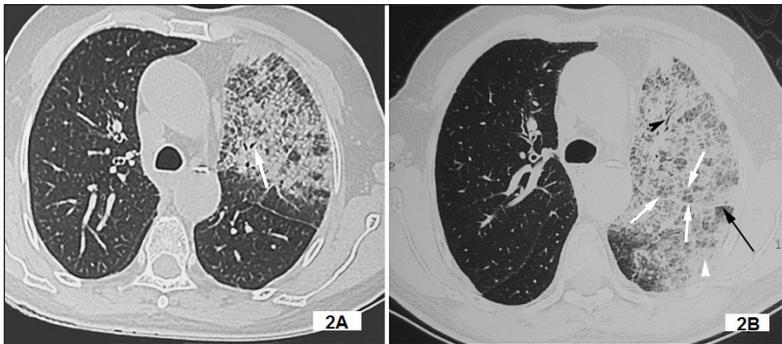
High-resolution computed tomography scan of the thorax (specifically the lung window), performed one year before presentation. The white arrow indicates evidence of air bronchograms amid consolidation in the left upper lobe, which suggests a unilateral "crazy-paving" pattern involving the left upper lobe.
